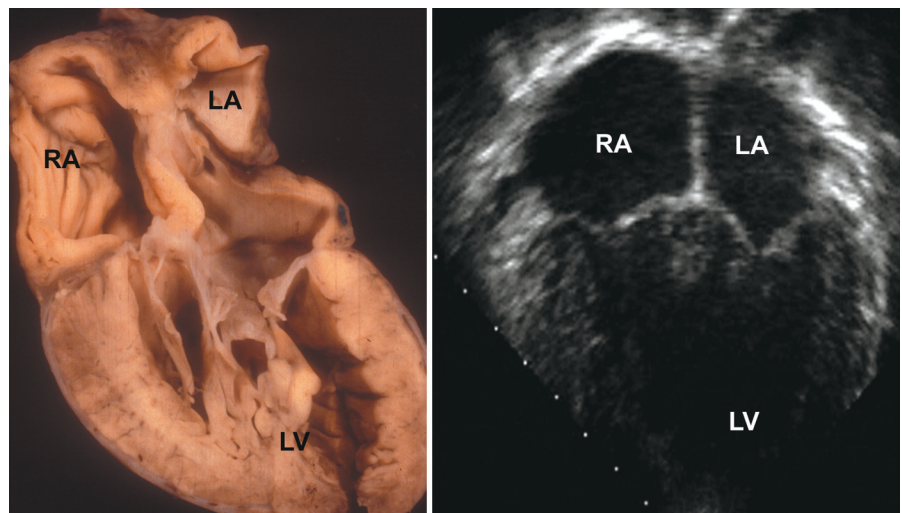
Apical four-chamber view of a double-inlet univentricular connection of the left ventricular type with two AV valves. LA = left atrium; LV = left ventricle; RA = right atrium.
